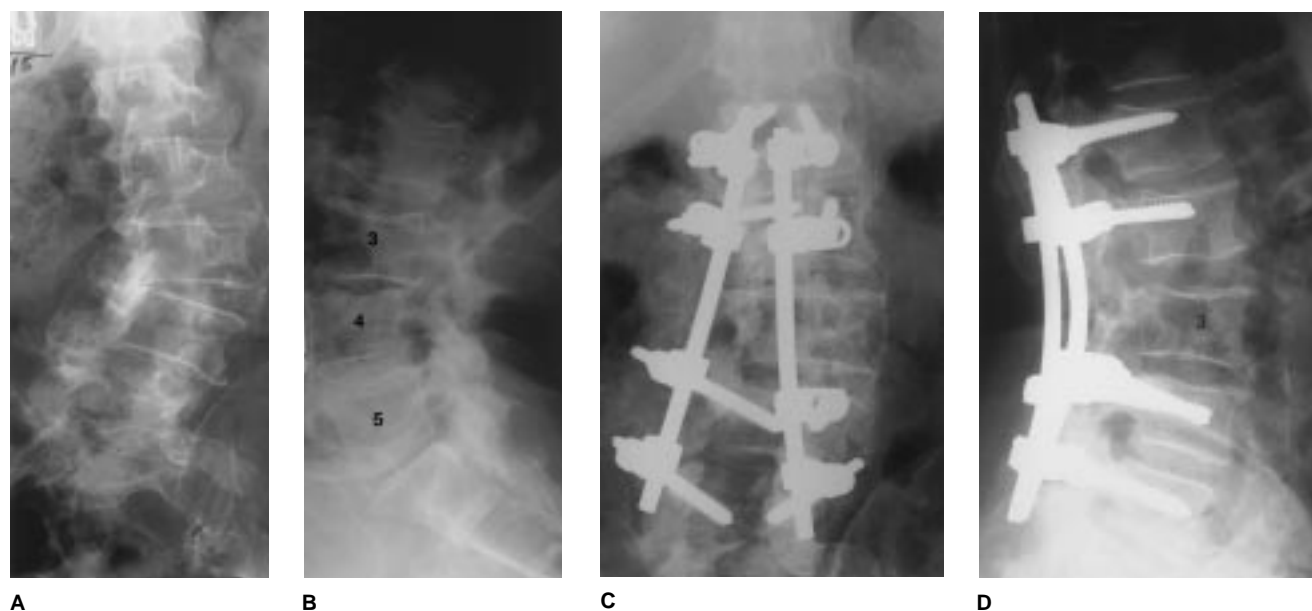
A, AP radiograph depicts degenerative lumbar scoliosis. B, Lateral radiograph of the degenerative lumbar curve. C, Postoperative AP radiograph shows the midline decompression and arthrodesis of the lumbar scoliosis with instrumentation. D, Postoperative lateral radiograph depicts the pedicle-screw instrumentation from L1 to L5. The sagittal contour of the lumbar spine is well maintained.
